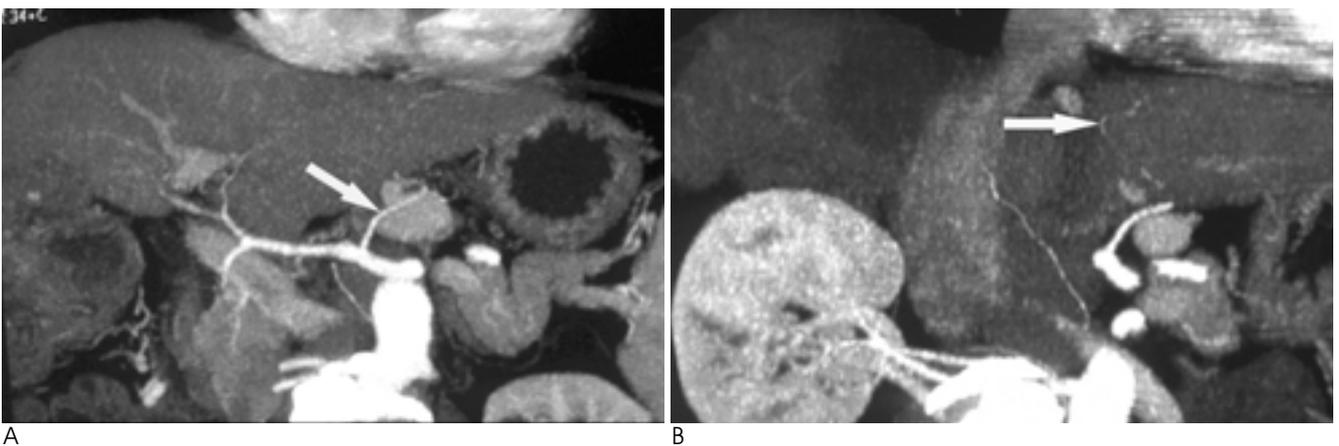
Type I of Michels classification. Oblique coronal three-dimensional CT angiograms (A and B) show that faint and small branch (arrow) of left gastric artery passes overlying left hepatic lobe and left gastric artery mimics accessory left hepatic artery. Because reader A misread small branch of left gastric artery as accessory left hepatic artery, he misestimated hepatic arterial anatomy as type V. Image quality is estimated as fair degree, because 2nd and 3rd branches of hepatic artery is seen faintly in 3DCT.
